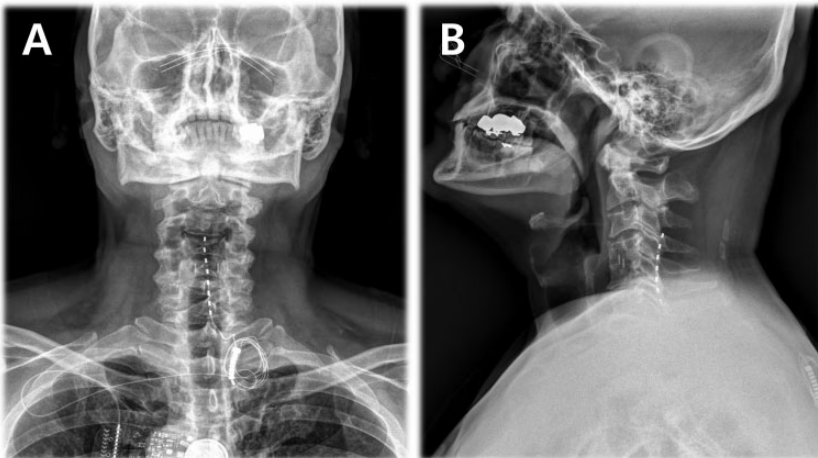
Anteroposterior view (A) and lateral view (B) plain X-rays taken after trial lead placement in a 59-year-old male patient (case 1) that presented with severe pain in both upper extremities secondary to a suspected spinal cord injury subsequent to a cervical interbody fusion surgery at C4–C5. He complained of sharp, tingling and scratching pain over 9 years and paroxysmal pain similar to an electric shock lasting approximately 5 min, more than 20 times a day. A single eight-contact lead was placed at the distal contact at the C3 vertebral body and the leads were positioned slightly to the left of the anatomical midline. A second lead could not be placed due to adhesion in the epidural space.
